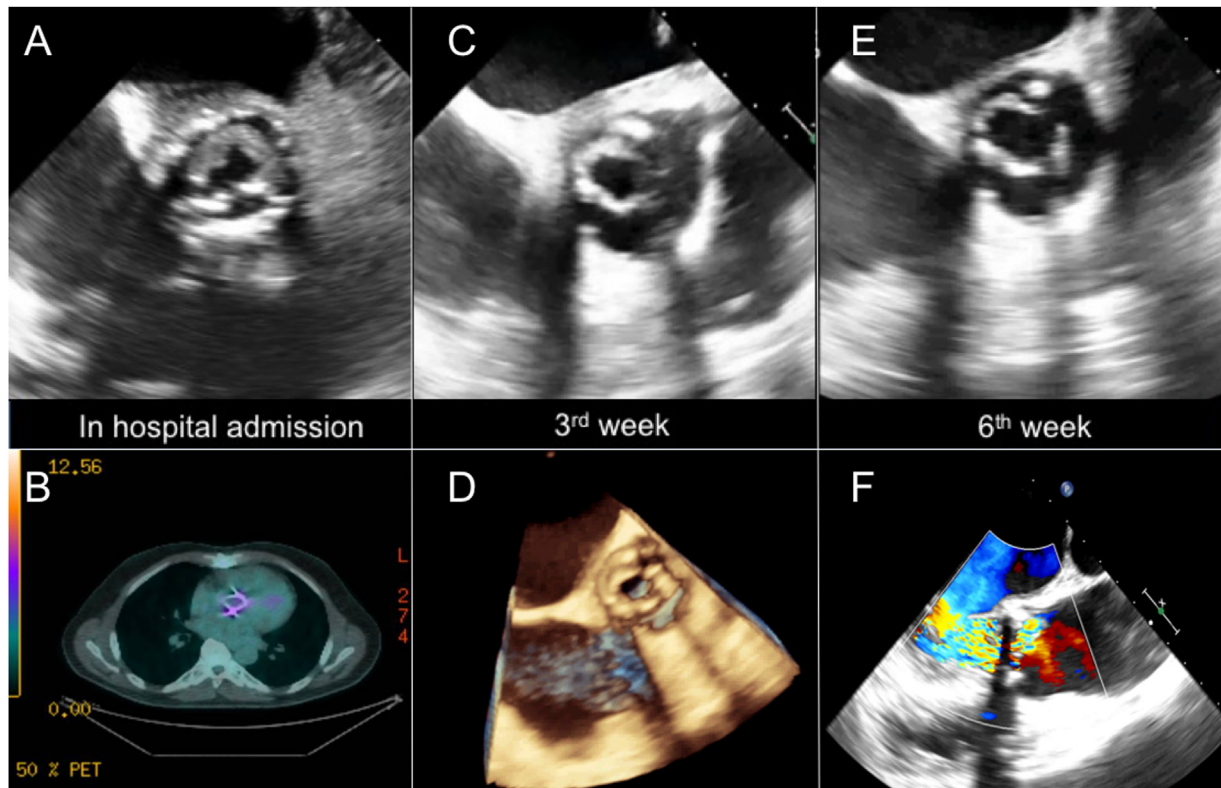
Step-by-step imaging of aortic prosthetic *Lactobacillus plantarum* endocarditis. (A) Baseline two-dimensional transesophageal echocardiogram showing marked fibro-plastic thickening of the cusps (free edges), commissural fusion, and reduced opening in systole causing severe stenosis. (B) ^{18}F -FDG-PET/CT showing tracer accumulation close to the aortic valve. (C) Reduction of the cusp thickening, improvement of commissural opening, and moderate stenosis. (D) Three-dimensional echocardiogram confirming the two-dimensional findings. (E) Further reduction of the cusp thickening and disappearance of commissural fusion. (F) Severe aortic regurgitation due to marked fibrotic retraction of cusps and degeneration.
